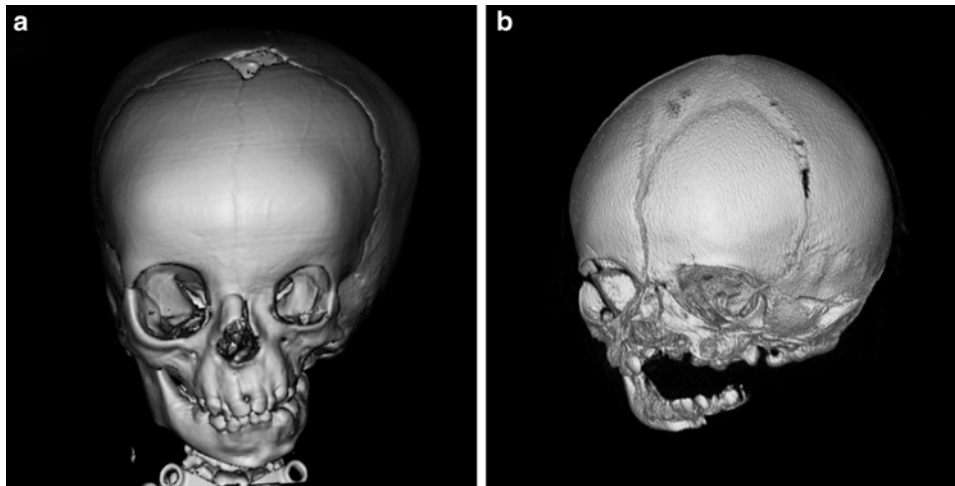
Craniofacial microsomia. (a) Three-dimensional reconstructed image from CT images shows left sided maxillary and mandibular hypoplasia resulting in facial asymmetry and airway narrowing-note the tracheotomy tube flange in the inferior aspect of the image. (b)
